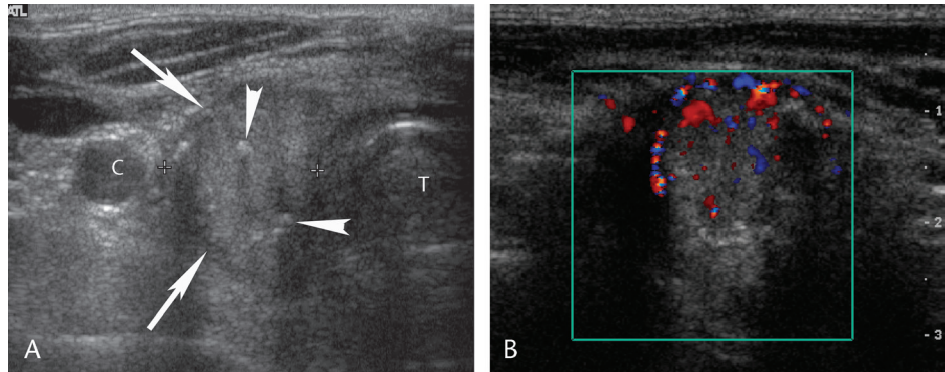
A 66-year-old man with a history of thyroidectomy for PTC 2 years ago with suspected residual tumor at the time of surgery. A, Transverse US of the right side of the neck, level VI, shows a 1.2×1.4 heterogeneous mass (arrows) with punctate calcifications (arrowheads) in the right surgical bed. The mass is displacing the common carotid artery (C) laterally. T indicates trachea. B, Color Doppler US of the mass shows increased vascularity. The US-guided FNA of this mass yielded metastatic PTC.
